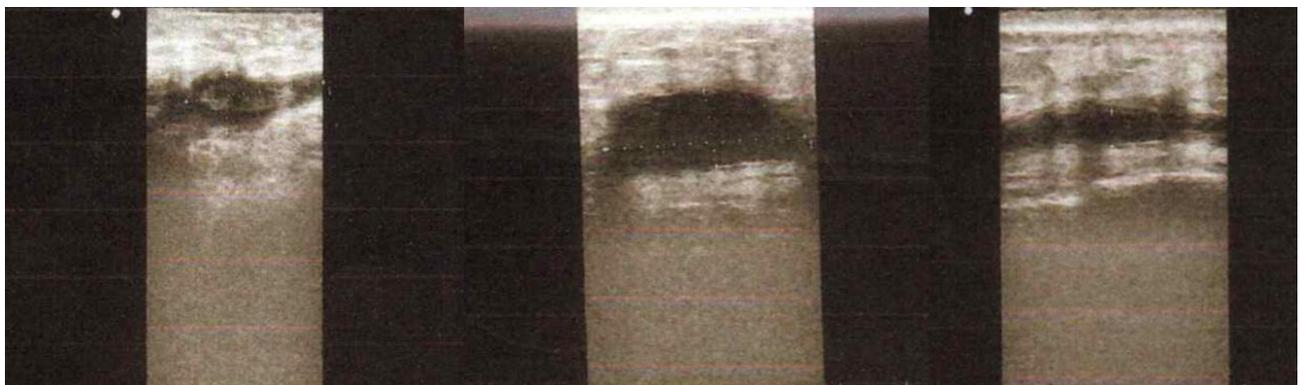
Breast Ultrasonography – 12.01.2018
